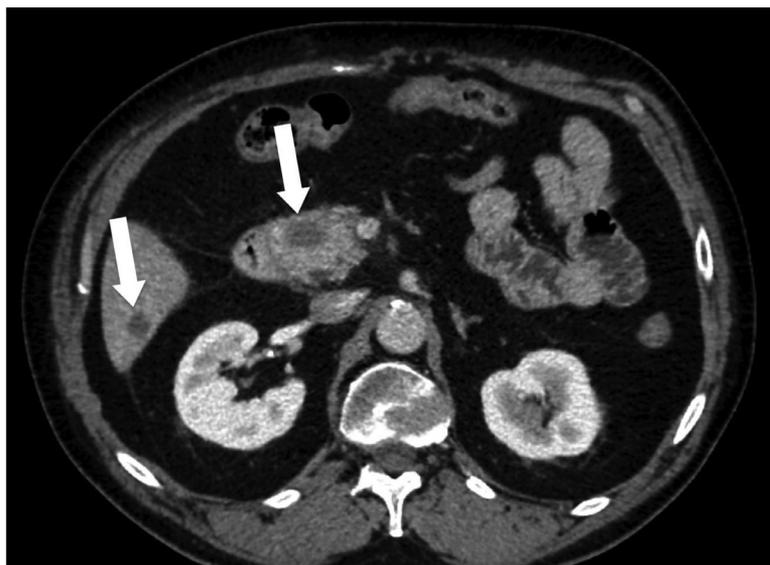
Pancreatic and hepatic metastases from primary lung adenocarcinoma in a 57-year-old male patient. Contrast-enhanced CT image obtained during portal venous phase shows two ill-defined hypoattenuating lesions (arrows) in the pancreatic head and in segment VI of the liver consistent with metastases.
